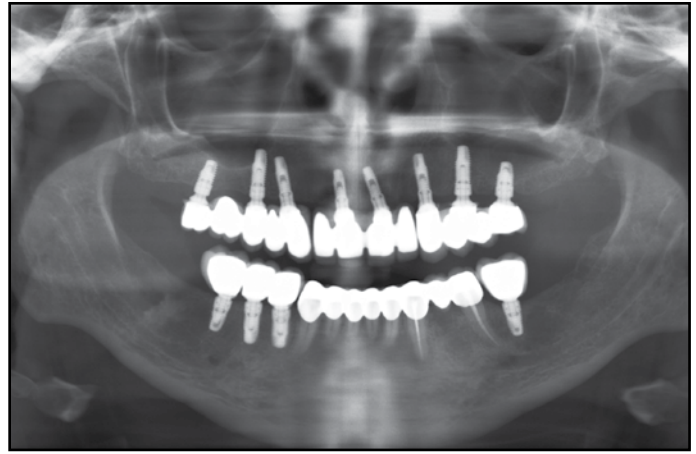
Panoramic x-ray after four months of function.
